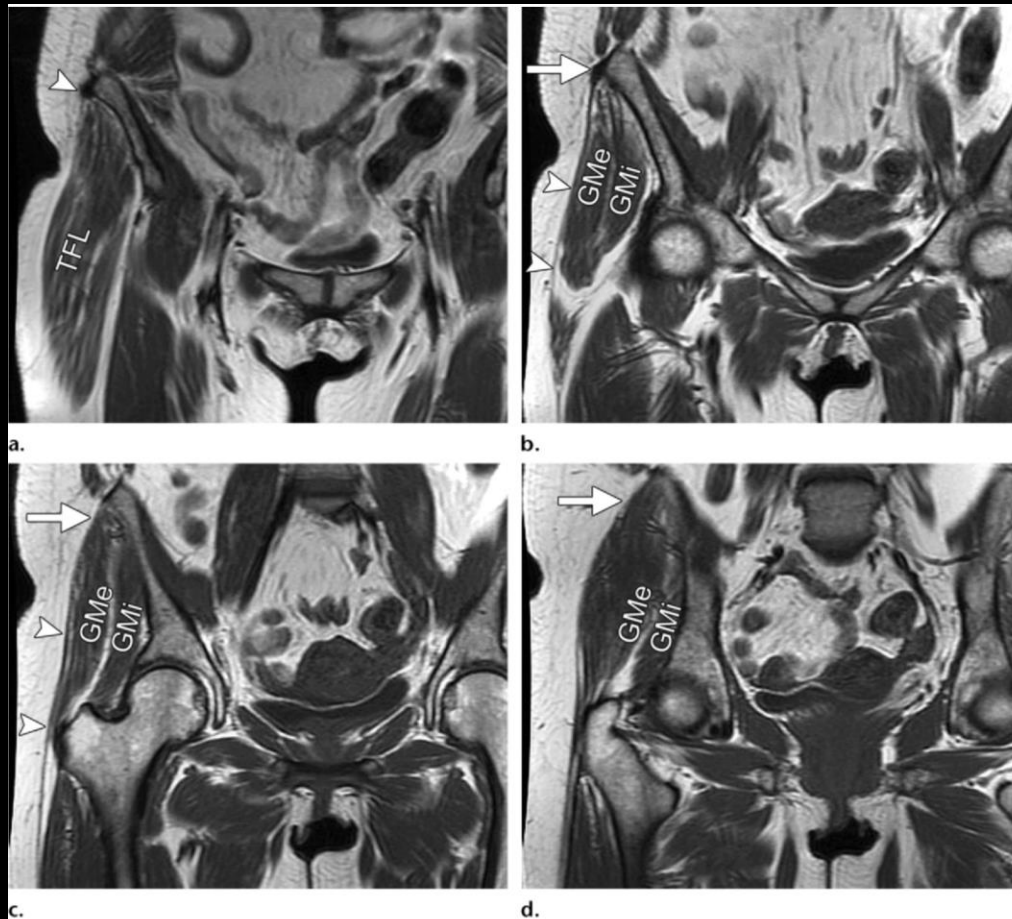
Coronal T1-weighted MR images (repetition time msec/echo time msec = 516/13) of the right hip in an asymptomatic volunteer show the attachment of the FL and its contributions from anterior to posterior. (a) The origin of the TFL, seen at the iliac crest, is covered by the ITB at the outer lip (arrowhead) of the iliac crest. (b) The more posterior portion of the ITB is well demonstrated at the iliac tubercle (arrow), as is the remainder of the ITB as it descends laterally along the thigh (arrowheads). Deep to the ITB are the gluteus medius (*GMe*) and gluteus minimus (*GMi*). (c, d) At the level of the hip joint, some fat separates the ITB from the gluteal muscles, which helps define the ITB at radiography. Posteriorly, the GA fascia (arrow) covers the upper part of the lateral surface of the gluteus medius—also giving rise to the gluteus maximus at its inferior border—and blends with the posterior fibers of the ITB (arrowheads in c).
